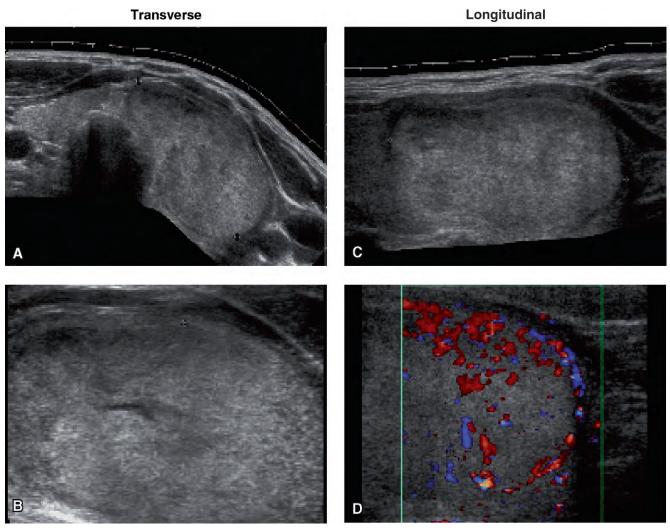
Ultrasound of follicular adenoma in the left lobe. A, Transverse diameter: 45 mm. B, Transverse. C, Longitudinal, sagittal diameter: 50 mm. D, Color Doppler, longitudinal.
